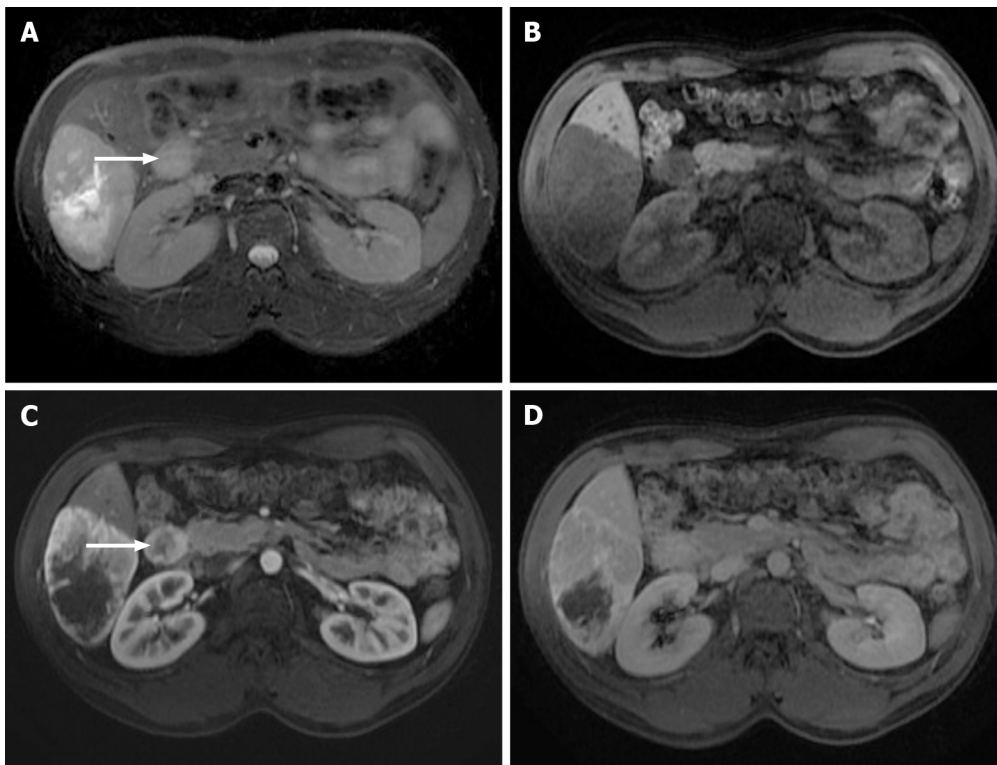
Images show a large liver metastasis from a duodenal neuroendocrine tumor. A: In the axial fat saturated (FS) T2-weighted imaging (WI), the liver metastasis is characterized by hyperintense central necrosis delimited by a lesser intense viable tumor. Note the duodenal neuroendocrine tumor (arrow); B: Axial FS non-contrast-enhanced magnetic resonance imaging (CE-MRI) T1-WI shows large hypointense liver metastasis; C: Axial FS CE-MRI T1-WI in the arterial phase demonstrates viable tumor with avid heterogeneous enhancement. The primary lesion is also hypervascular and depicted in the 2nd portion of the duodenum (arrow); D: Axial FS CE-MRI T1-WI in the interstitial phase reveals fading of the lesion.
